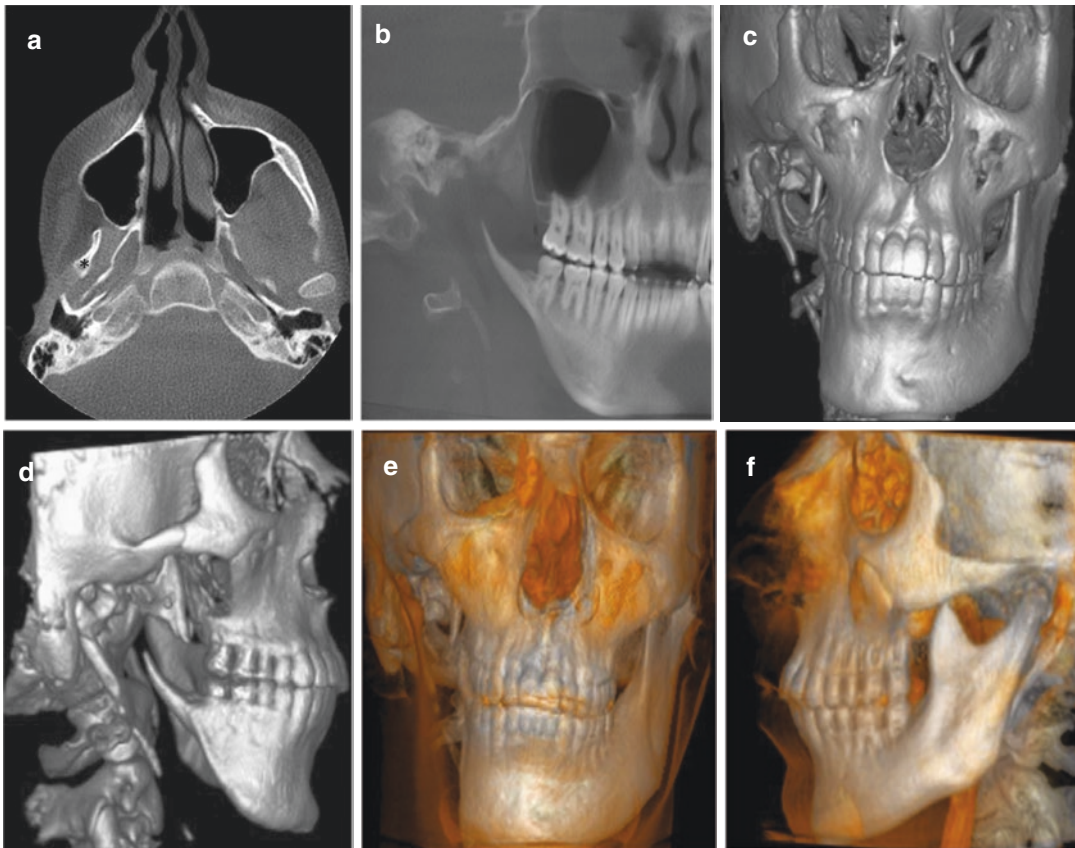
Goldenhar syndrome is a rare condition characterized by facial asymmetry, deformation (microtia) or absence of the ear (anotia), ocular dermoid cysts, and spinal abnormalities. Transversal digital volume tomography (DVT) (a) based on cone beam computed tomography (CBCT) reveals a spur-like hypoplasticity of the right mandibular ramus and an abnormal condylar process (*)
